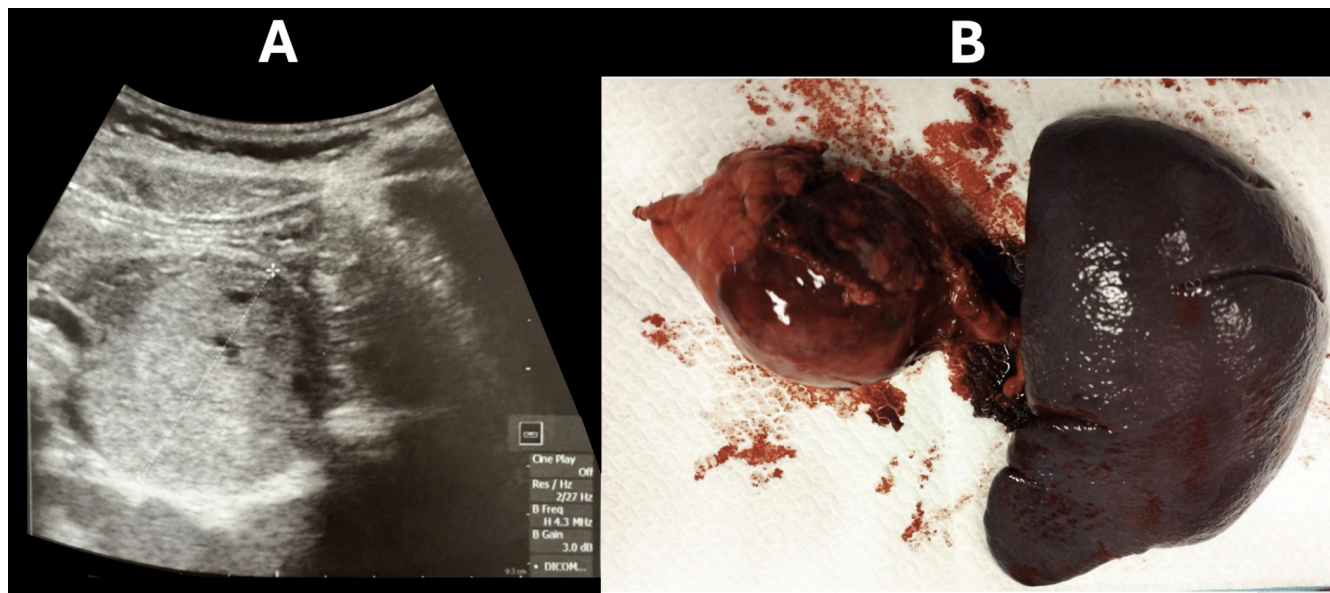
Ultrasound print of the SPN (A) and postoperative image showing the excised tumor and spleen (B).
